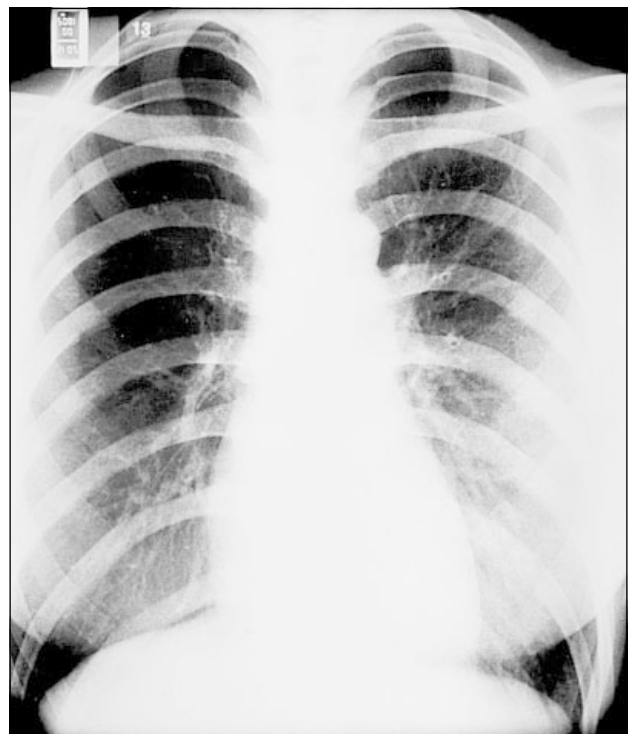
Chest radiography at presentation showed clear lung parenchyma, a diminutive right hilum, and hypoperfusion of the right lung.
